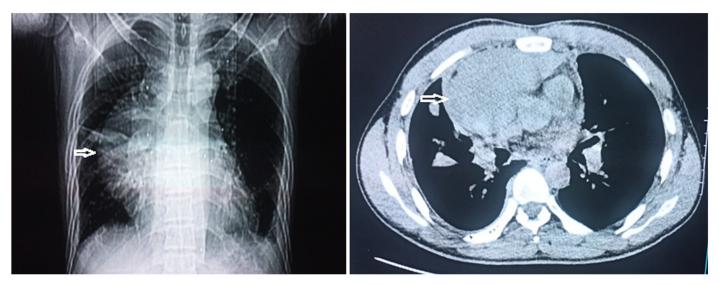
(a) Chest radiograph showing enlargement of the right mediastinum (b) Chest Computed Tomography (CT) scan showing a large.
